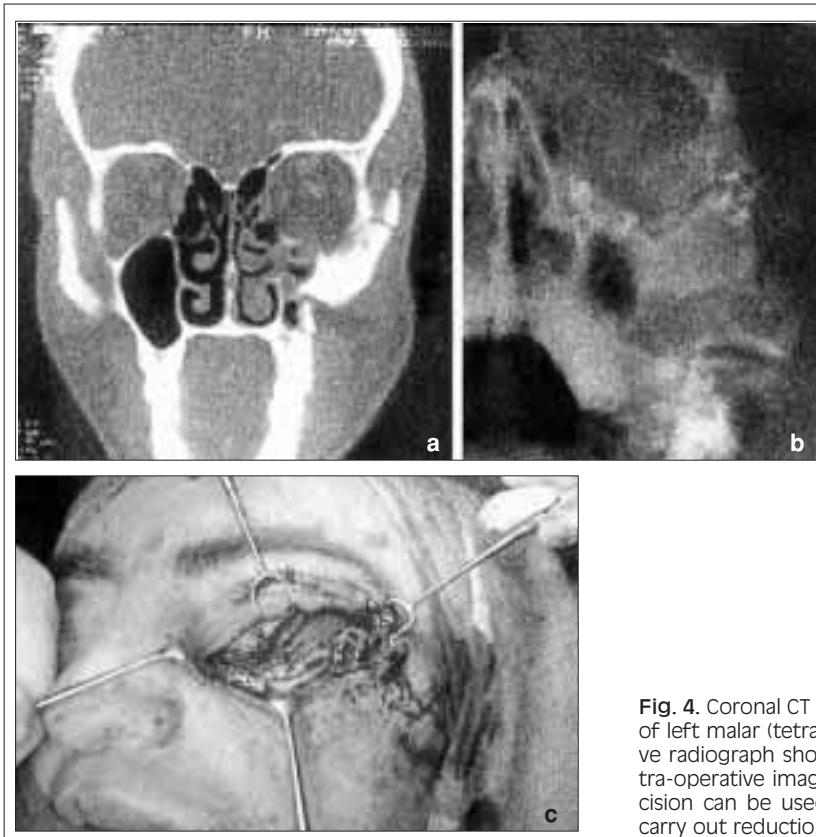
Coronal CT of complete mono-fragment fracture of left malar (tetrapod fracture) (a). Direct post-operative radiograph showing repair with 2 mini-plates (b). Intra-operative image: laterally prolonged infra-orbital incision can be used to expose rims of fracture and to carry out reduction and fixation (c).
